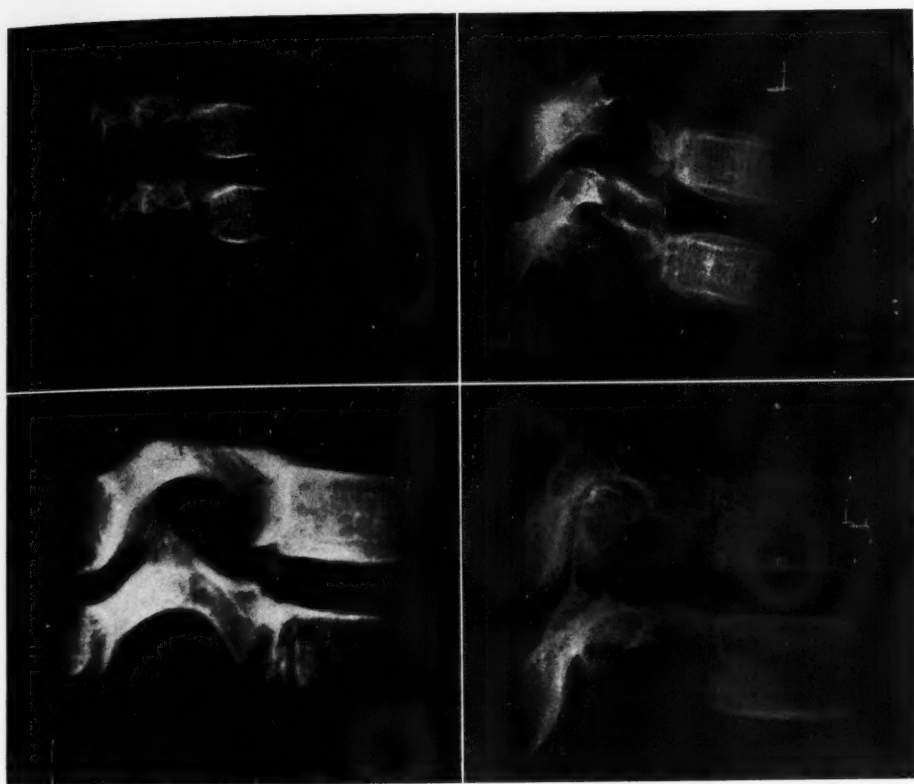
Lateral roentgenograms of the dorsal vertebrae: (A) (*upper left*) at birth; (B) (*upper right*) 6 months; (C) (*lower left*) 1 year; (D) (*lower right*) 2 years. Well calcified articular facets are seen first in C.
